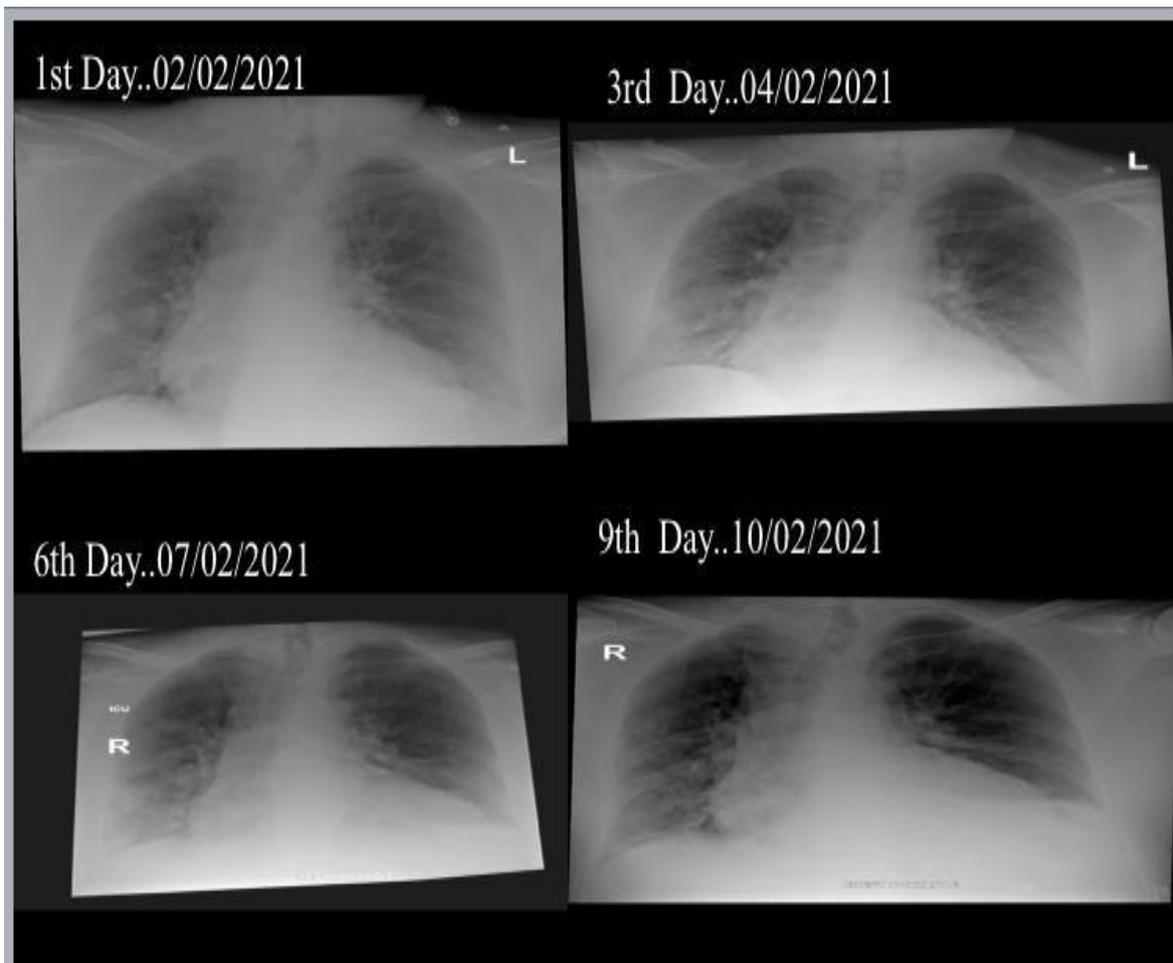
Serial chest x-ray on the 1st, 3rd, 6th, and 9th day
